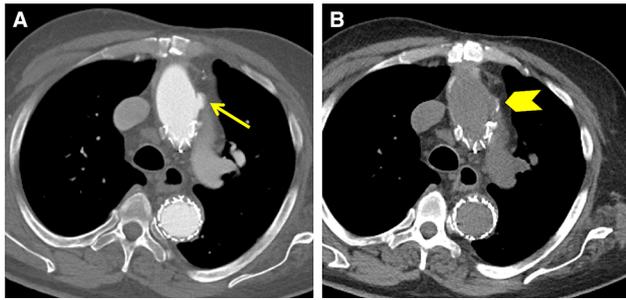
Bypass cannulation site. a Post-contrast CTA images demonstrate a focal hyperdensity along the outer contour of the aortic arch (arrow) suggesting pseudoaneurysm. b Non-contrast images demonstrate intrinsic hyperdensity correlating with this area, compatible with a bypass cannulation site (arrowhead). This is a typical location for bypass cannulation, and should not be confused with a post-operative pseudoaneurysm
